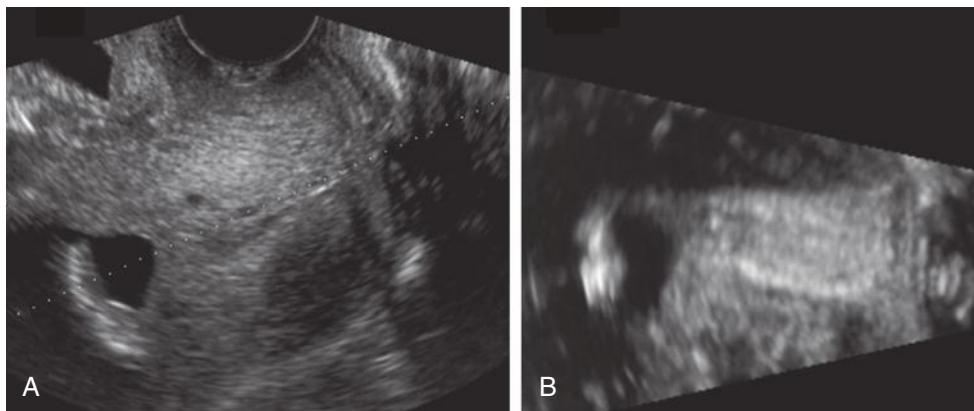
Virtual contrast imaging (VCI) of the cervix, also referred to as thin volume imaging. Two-dimensional (2D) sagittal ultrasound image of the cervix (A) displayed simultaneously with a VCI-derived image of the cervix in the coronal plane (B). This dual view enables the operator to evaluate the cervix in real time in both the sagittal and the true coronal planes. This is done by properly placing the dotted line along the preferred axis in the 2D image, as shown in A.
